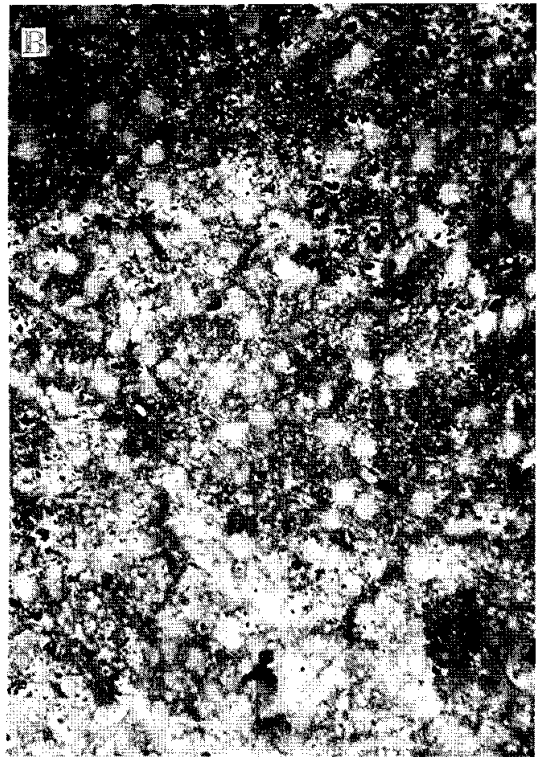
High-resolution CT (A) and photograph of the sliced lung surface (B) showing miliary tuberculosis.
